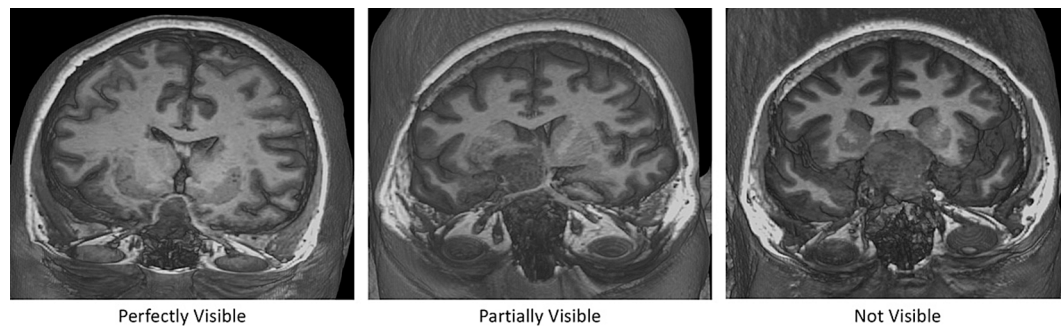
3D reconstructions of a 3D MPRAGE T1-weighted image of three different patients with SPTs in which the AOP was visually judged to be “perfectly visible” (left), “partially visible” (center) and “not visible” (right).
